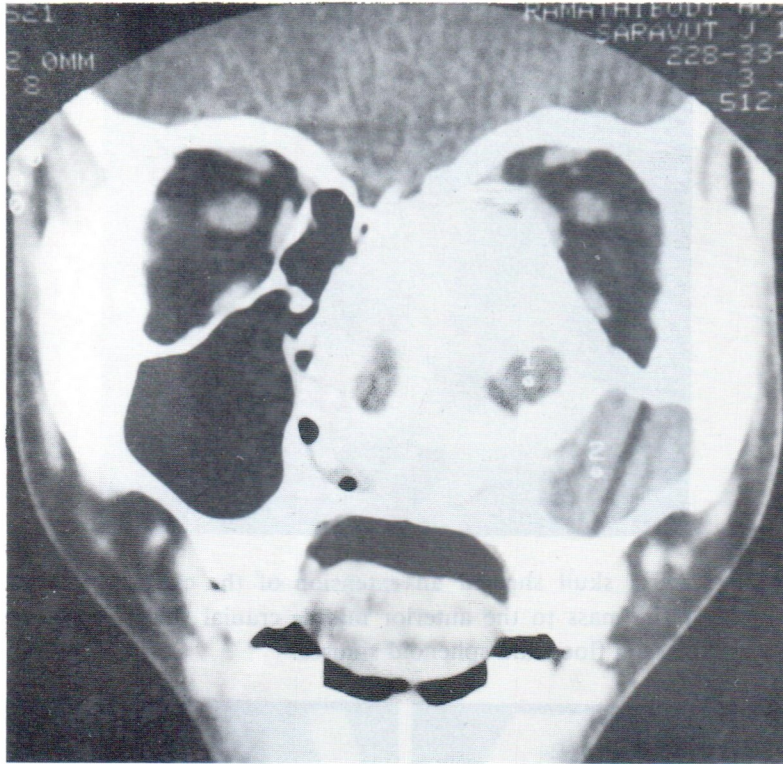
Case 1. Coronal CT scan of the face showed a well defined border mass, size $4.5 \times 5 \times 5$ cm, in the left nasal cavity, extending to left ethmoid sinus, left maxillary sinus and left orbital cavity. The mass was densely calcified or ossified. Retention of fluid in left ethmoid and left maxillary sinus was observed. There was no destructive behavior of the mass
